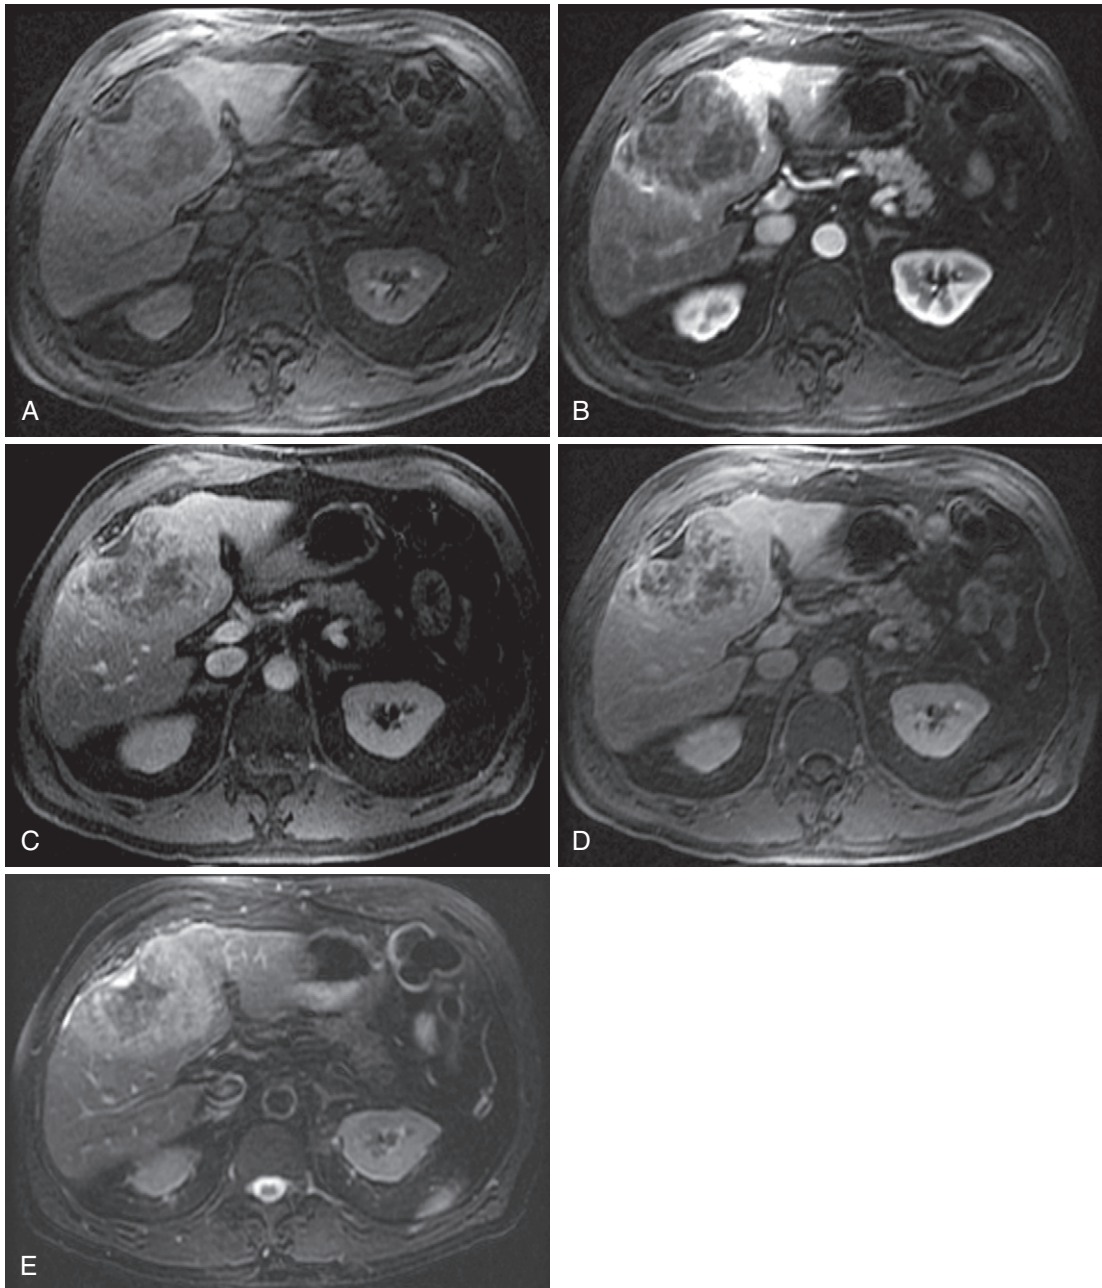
Cholangiocarcinoma signal and enhancement patterns. Mild patchy enhancement of the central aspect of the large peripheral cholangiocarcinoma on the arterial phase image (B) compared with the precontrast image (A) progresses on the serial delayed images (C and D). E, Patchy central enhancement likely reflects a combination of coagulative necrosis and desmoplasia—both hypointense on the moderately T2-weighted image. Note the classic peripheral hyperintensity, central hypointensity, and capsular retraction.
